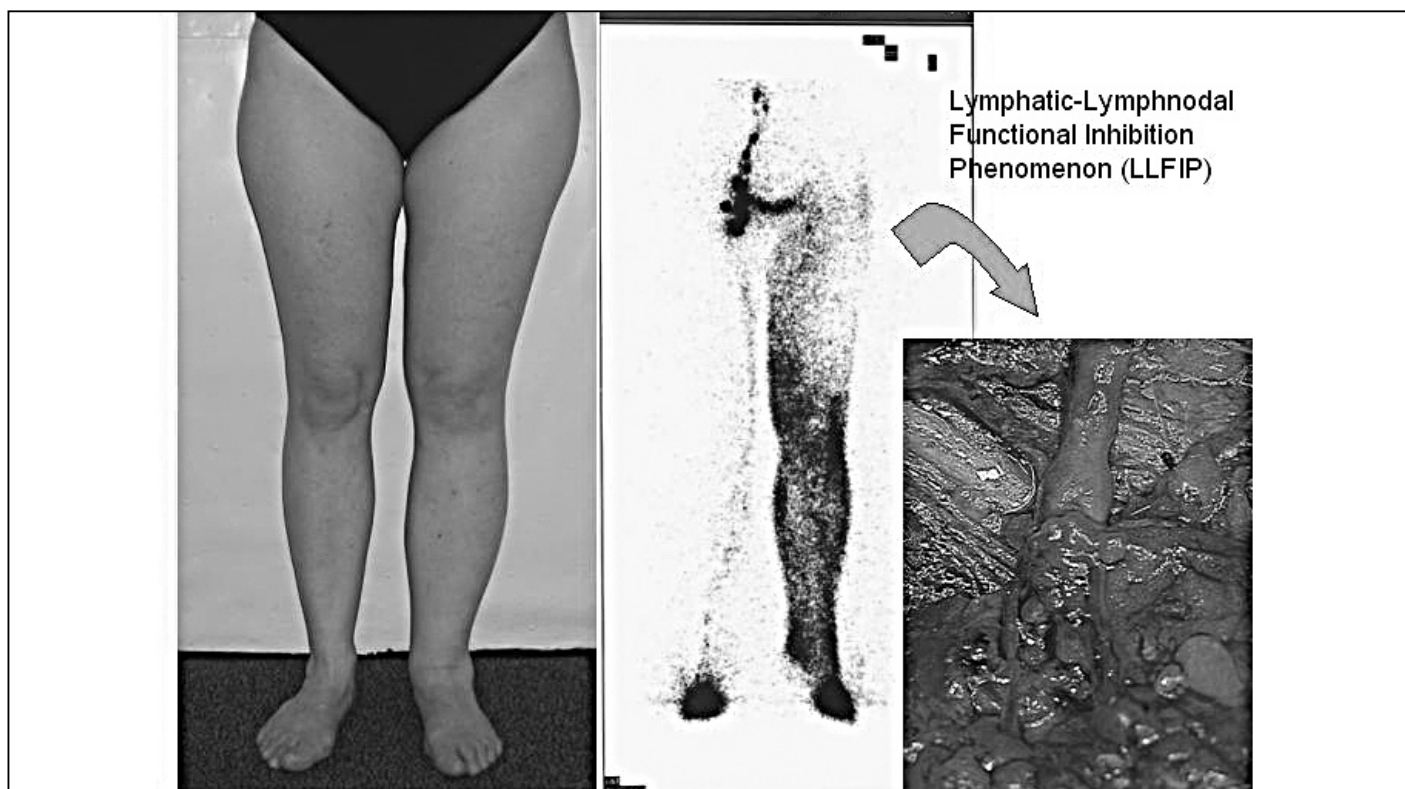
Lymphoscintigraphy in a case of peripheral early stage lymphedema showing the LLFIP phenomenon.
